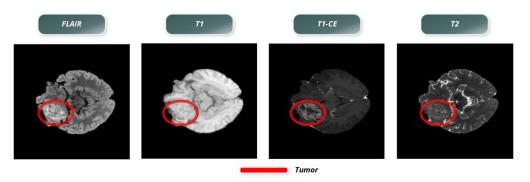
Four-modality MRI imaging of tumours
